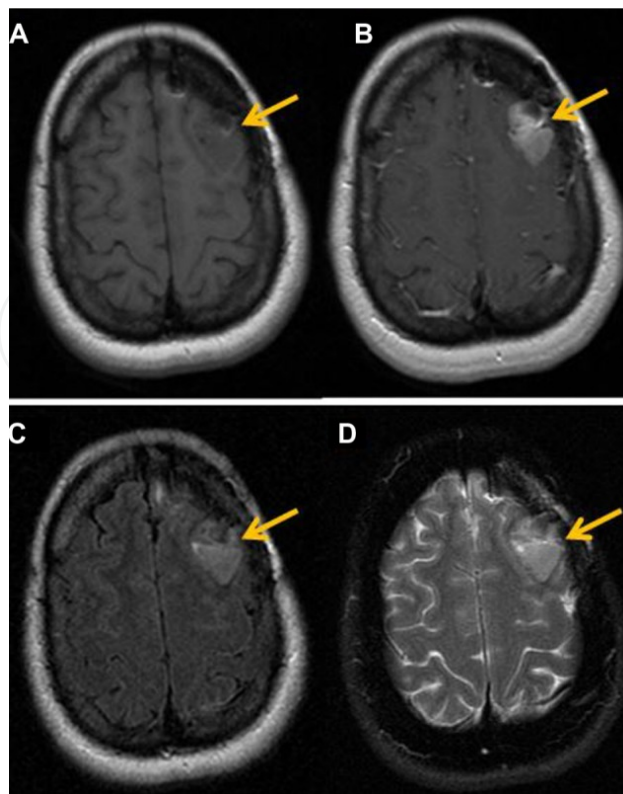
(A) T1 pre-contrast images exhibit a hypointense lesion in the left frontal lobe region (arrow). (B) Axial T1 post-contrast images, after injection of 20 cc of intravenous MultiHance®, demonstrate a focus of enhancement in left frontal lobe. (C) Axial T2 FLAIR images show increase in FLAIR signal in the left frontal lobe, which demonstrates enhancement. (D) T2 FSE images also demonstrate increase in signal in the region of the left frontal lobe.[30]
